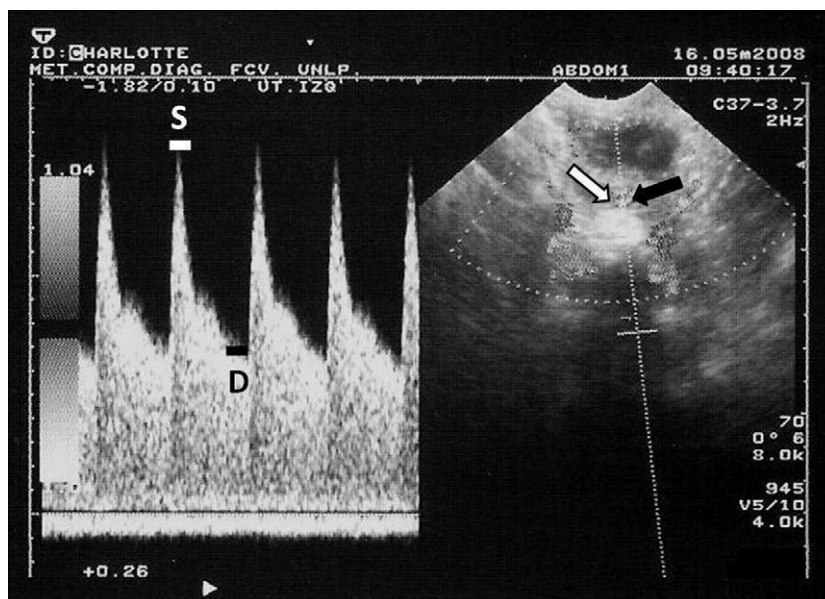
Pulsed wave Doppler ultrasound register of uterine artery (white arrow) in a selected pregnant bitch 60 days after the estimated day of the luteinizing hormone peak. The cursor was positioned on the artery (black arrow). *S* is the peak systolic velocity and *D* the end diastolic velocity.
